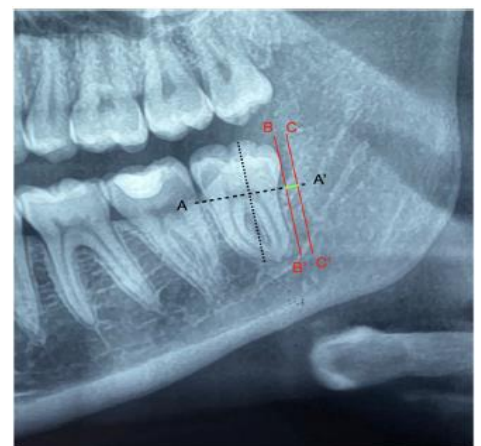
X-ray OPT measurement scheme for determining the extent of the DALM lesion
